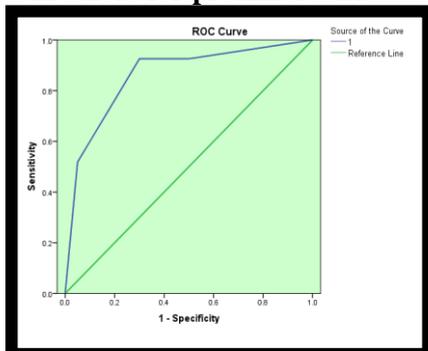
Receiver operating characteristic ROC plot: Bitewing radiograph at dentin threshold for proximal surfaces
